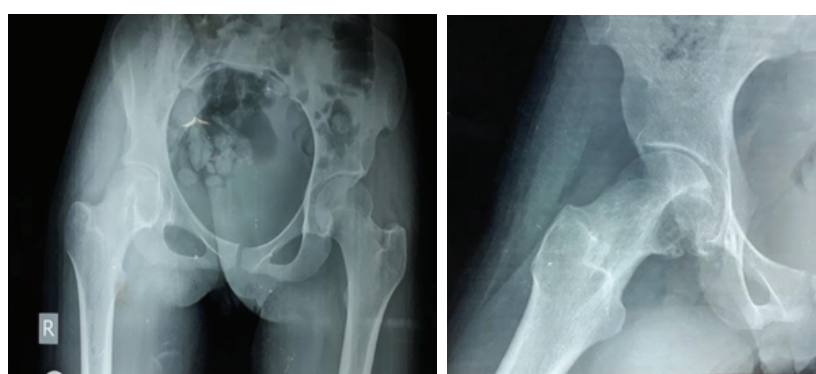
X-ray of the pelvis and right hip showing a large defect in the right femoral head
